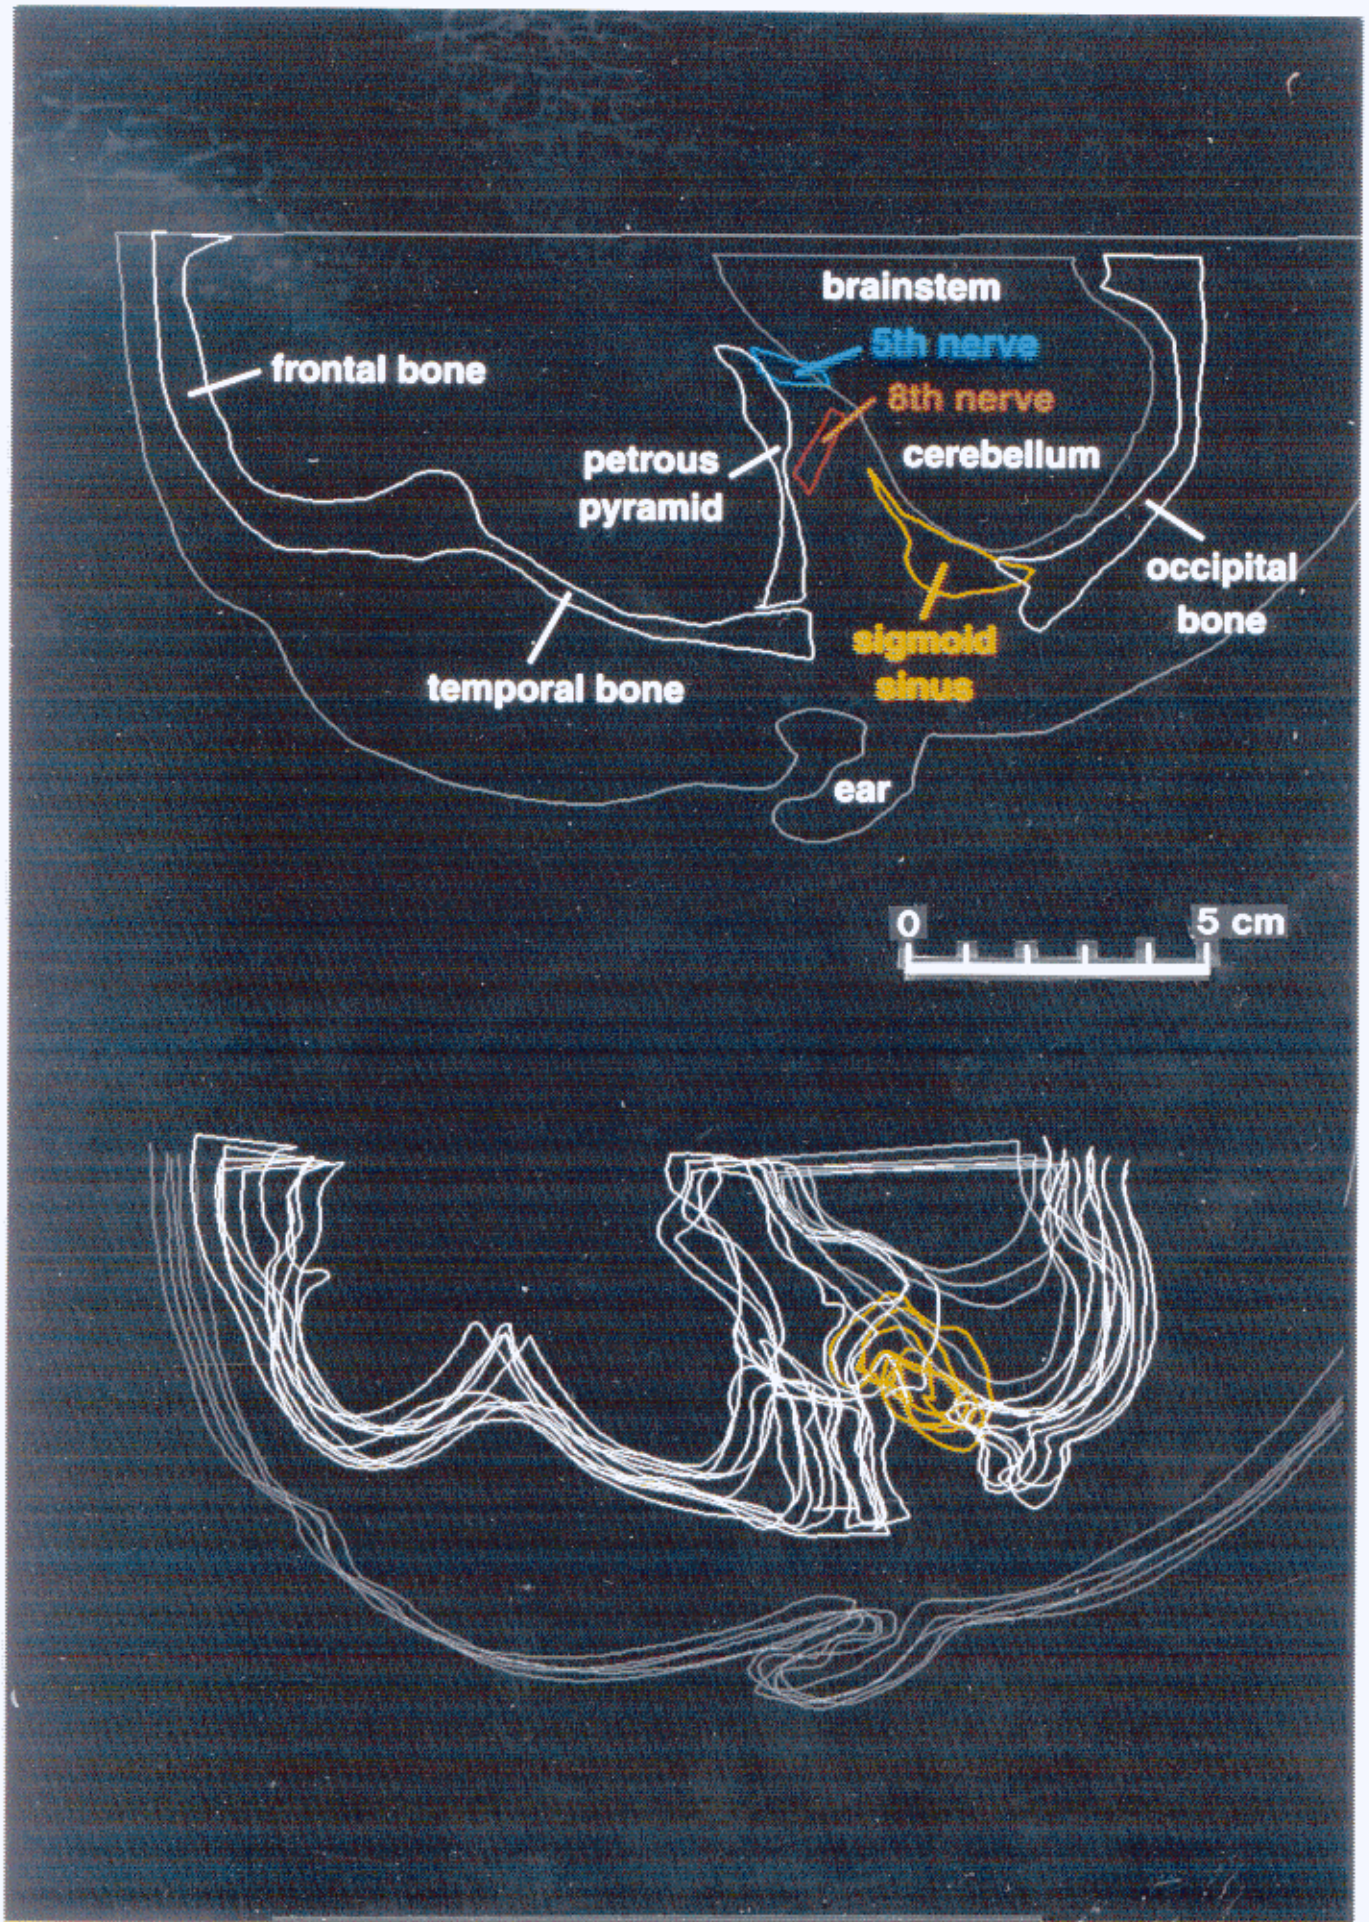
3D reconstruction of CT images
